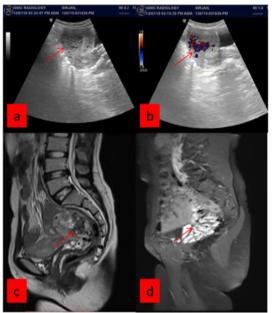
(a) USG showing cystic space (b) increased vascularity (c,d) MRI showing flow void and vascular congestion in pelvis.
